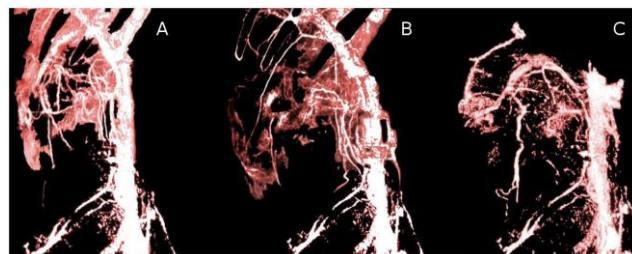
Abdominal CT Scan with vascular description in the 3D plane shows the vascular profile (3A) before RAE was performed, (3B) after 1st RAE, main renal artery was successfully blocked but remaining artery in inferior mesenteric and extrarenal collateral vascular supply cannot be blocked by RAE, (3C) after 2nd RAE was performed, it shows that tumor vascular supply in mesenteric inferior and collateral artery had minimized
